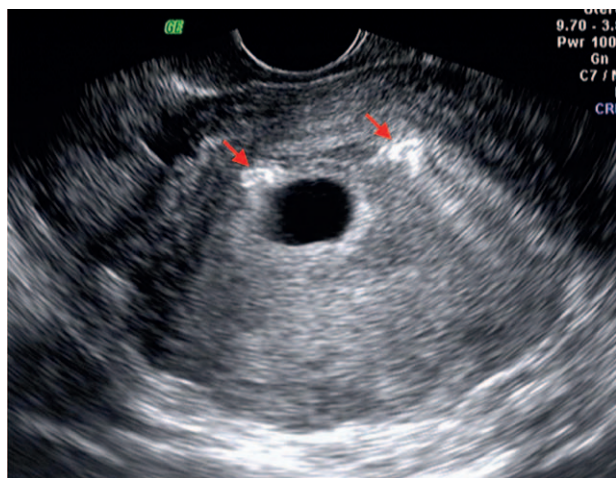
Ultrasound examination showing the MCu intrauterine device (IUD) (red arrows) during pregnancy. IUD = intrauterine contraceptive device, US = ultrasonography.
